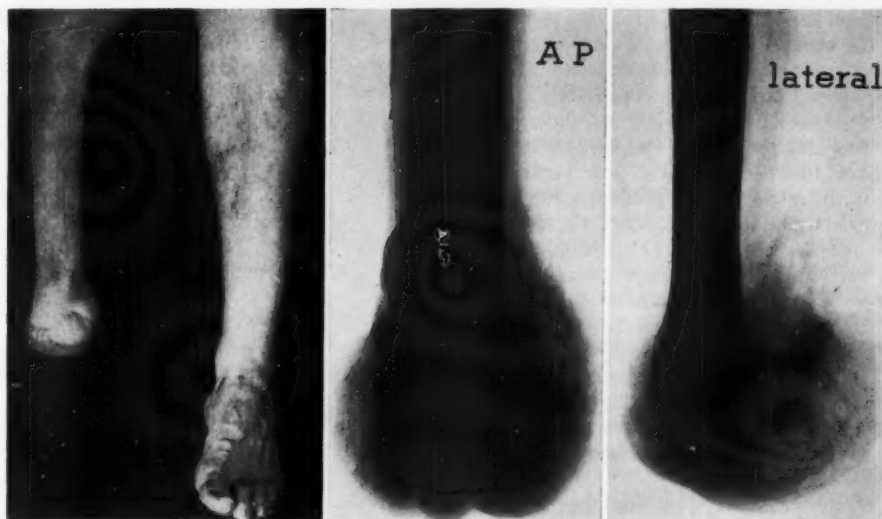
Lower extremities of a 70-year-old man whose Syme amputation was performed 65 years ago for deformed foot resulting from a severe injury at the age of two. Left, appearance of the stump; right, radiographs of the stump. The heel flap is large and soft, moves rather freely on the ends of the bones, and can be moved voluntarily by contraction of the tendo achillis. There is very little shortening of the tibia. Patient has led a very active life (squash-rackets champion at one time) and has had no trouble with his stump. He wears a Marks prothesis (wooden bucket closed with leather flaps over a tongue, solid ankle, and sponge-rubber foot).
